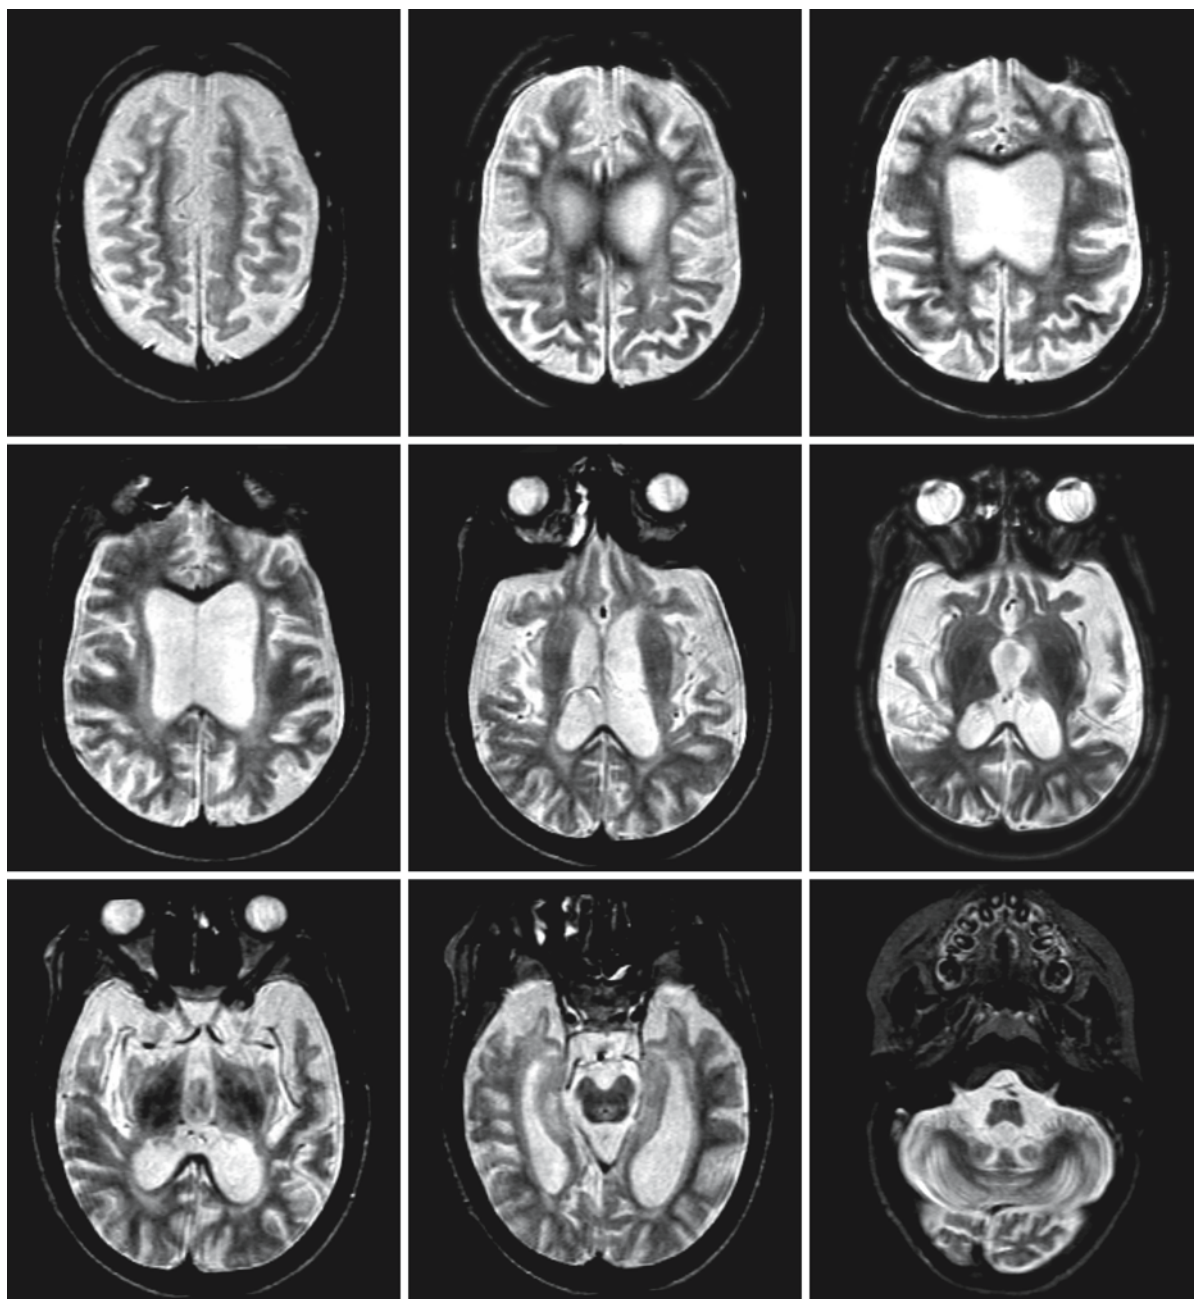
MRI in the same boy with TvLINCL, now 8 years old. Note the serious generalized atrophy involving cerebral hemispheres, basal ganglia, and cerebellum. The cerebral white
